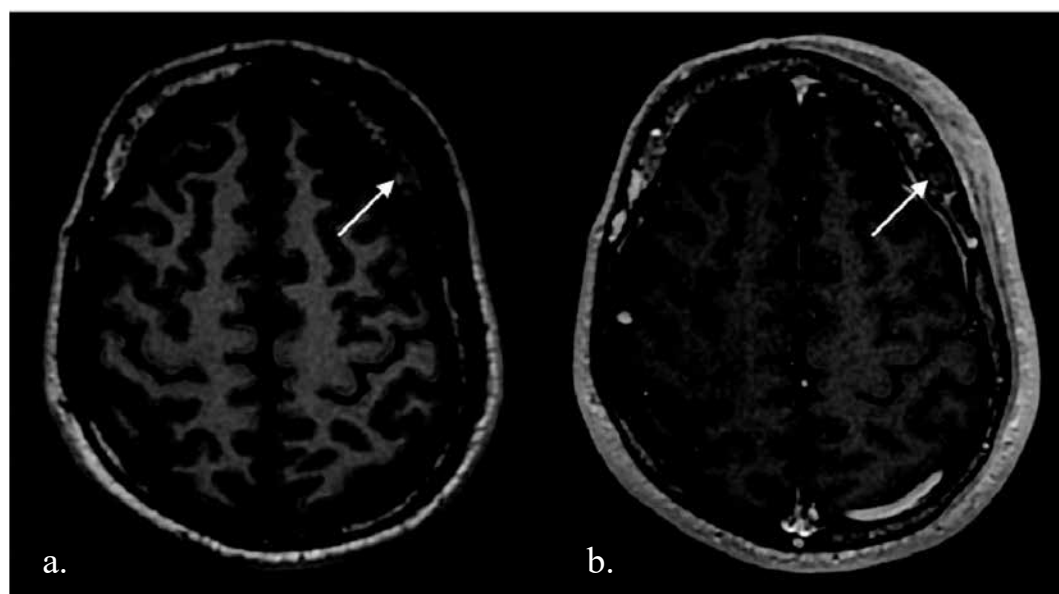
MRI T1-weighted images 3a before and 3b after intravenous contrast agent administration – isointense osteolytic lesion with weak enhancement after contrast agent administration (white arrow). Subcutaneous tissue edema.
